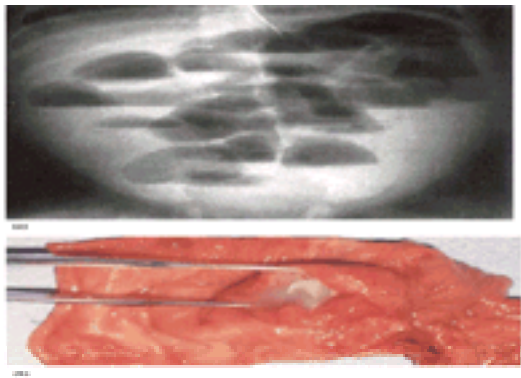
(a) Radiograph of a 10-week-old infant who presented with intestinal obstruction. (b) A cecal duplication was identified preoperatively by ultrasound performed to evaluate a palpable right lower-quadrant mass. The shared wall between the cecum and the duplication has been opened, demonstrating the mucus filling the duplication and producing obstruction by compressing the ileocecal valve.
